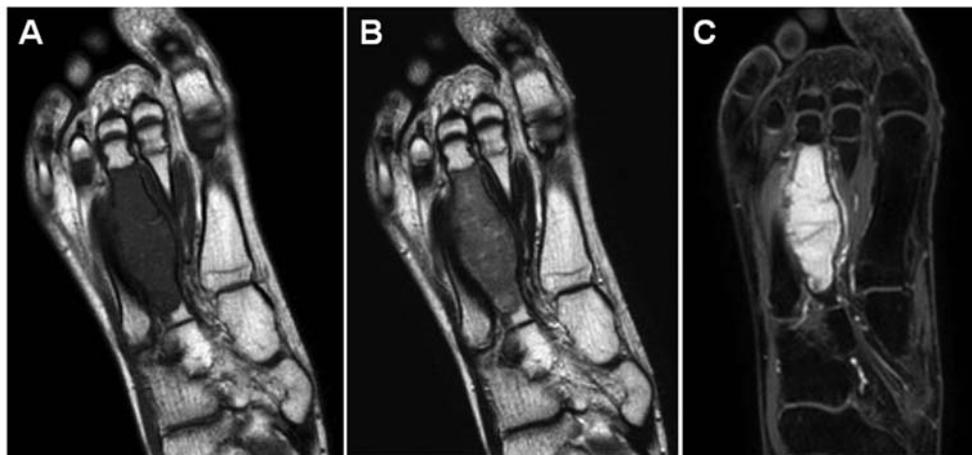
Coronal magnetic resonance images of low-grade central osteosarcoma involving the third metatarsal bone. The lesion exhibits intermediate signal intensity on T1-weighted sequence (A) and moderately-high signal intensity on T2-weighted sequence (B). T1-weighted contrast-enhanced fat-suppressed sequence reveals marked enhancement of the lesion (C).
